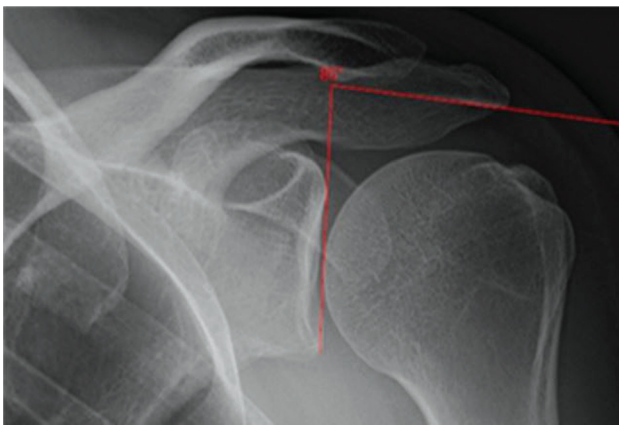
Determination of LAA on the AP radiograph of the shoulder joint according to the method described by Banas [6]
